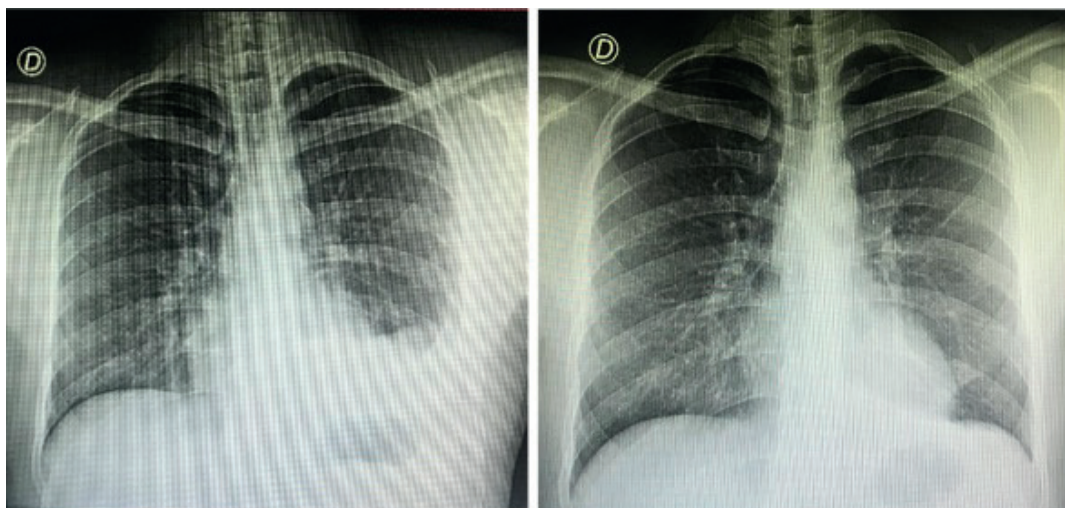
(A) Chest radiograph at hospital admission showing a left-sided pleural effusion. (B) Chest radiograph after performing a thoracentesis that yielded 650cc of an exudate liquid, showing significant improvement of the pleural effusion.
